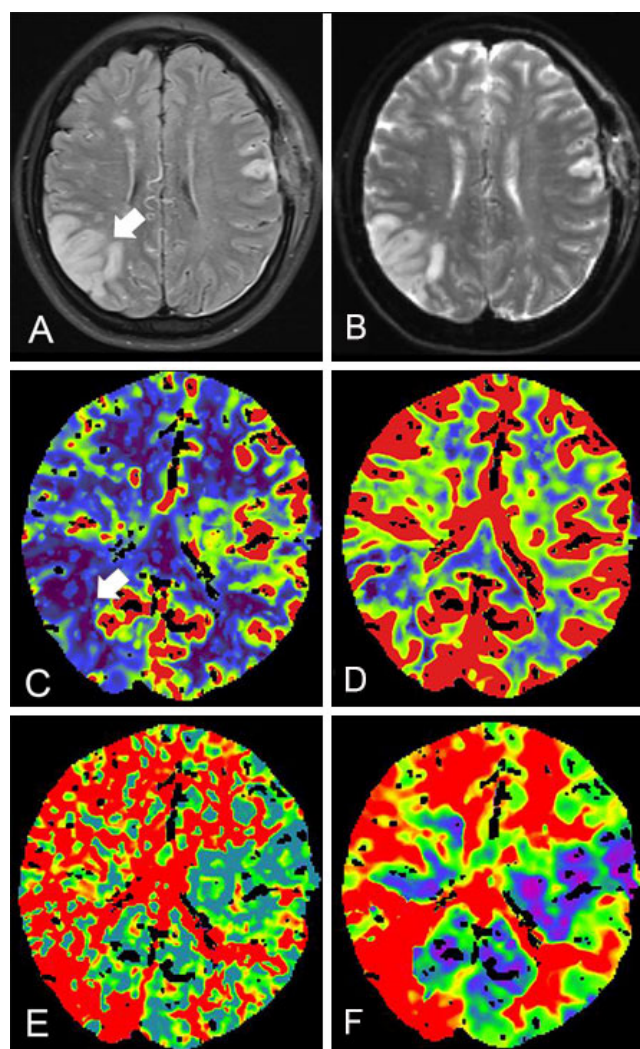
Postoperative magnetic resonance image and perfusion CT. MR image at postoperative Day 6 revealed a ischemic lesion (white arrow) of hyperintensity between the right parietal and occipital lobe on FLAIR (A) and DWI (B). Perfusion CT at postoperative Day 3 showed CBF (C) and CBV (D) reduced at the corresponding site. Regional MTT (E) and TTP (F) increased significantly. CT: computed tomography; CBF: cerebral blood flow; CBV: cerebral blood volume; DWI: diffusion weighted image; FLAIR: fluid attenuated inversion recovery; MTT: mean transit time; TTP: time to peak
